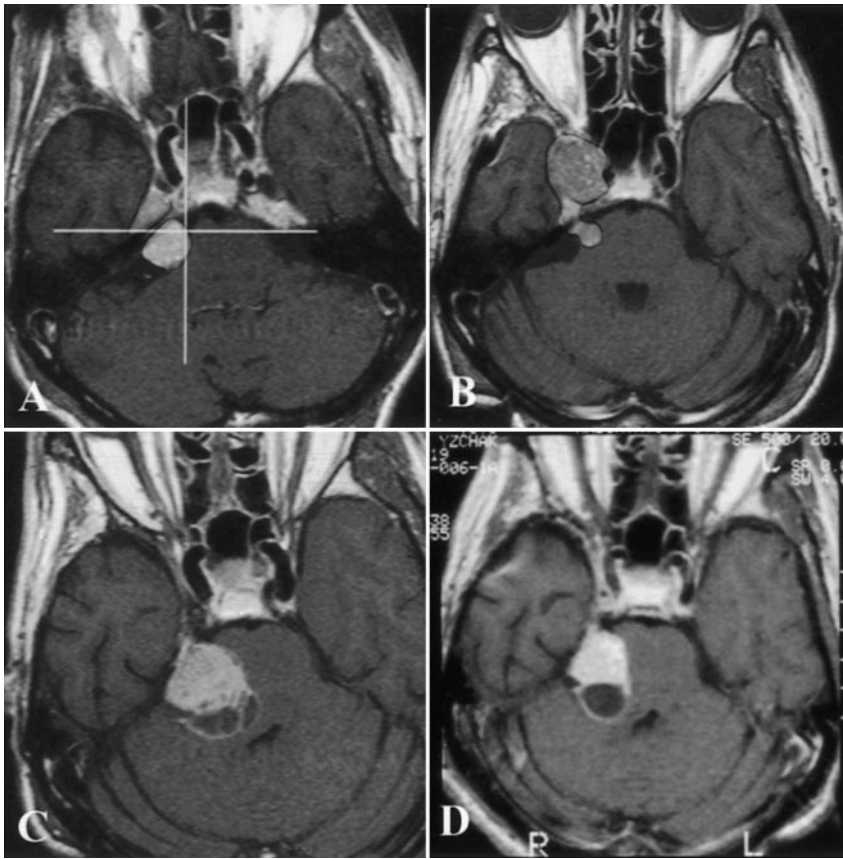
A 47 year old man with a right cerebellopontine angle hemangiopericytoma shown in the post contrast T1 weighted axial MRI obtained at the time of initial Gamma surgery (A). Forty months later the CP angle lesion was 90% smaller but there was a new tumor in the right cavernous sinus which was treated (B). Nine months later the cavernous sinus lesion was 80% smaller but the CP angle tumor progressed and was retreated (C). Three months following the last Gamma surgery the cavernous sinus tumor was stable and the CP angle tumor shrank 15%. (Patient 3, Table 1.)
